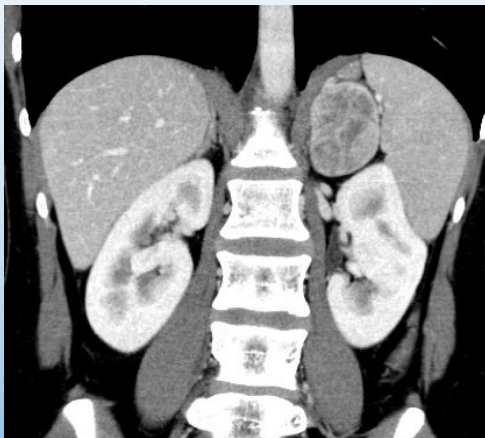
Contrast-enhanced CT of the abdomen shows a large left-sided adrenal mass (arrow).
